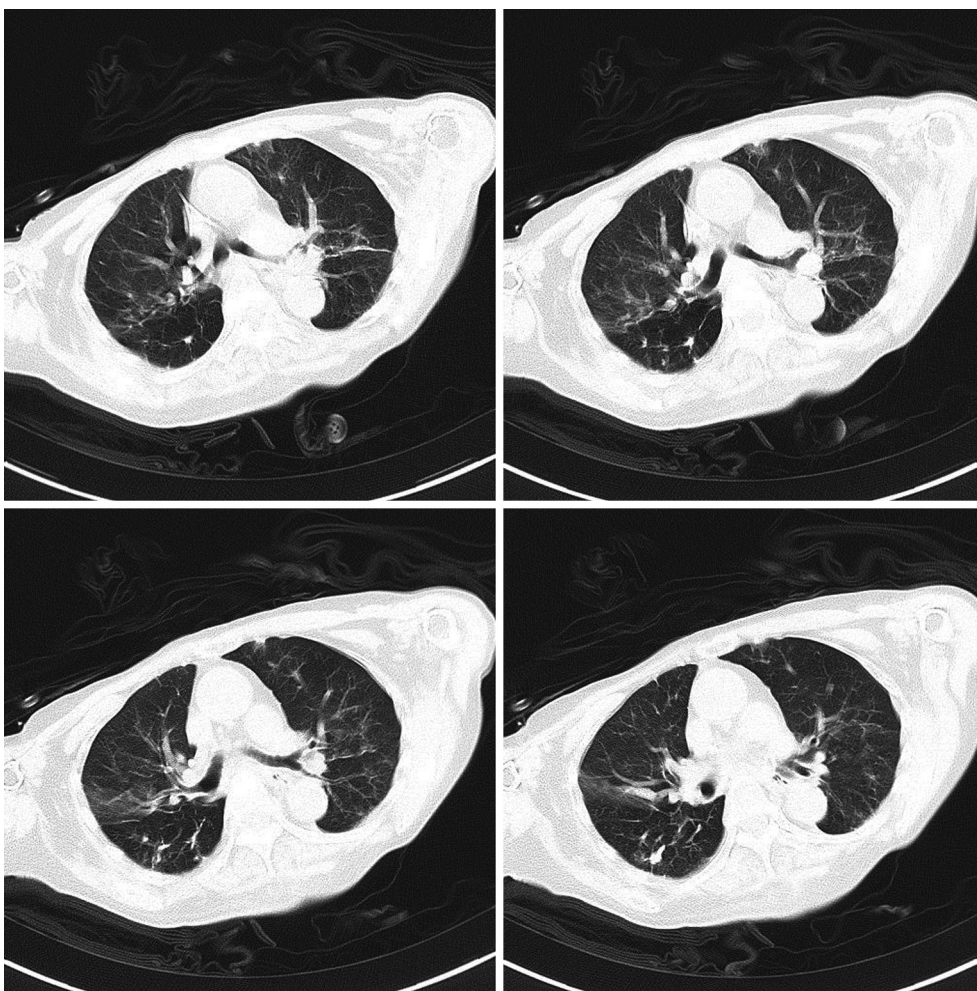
Chest CT scans shown signs of pneumonia.
